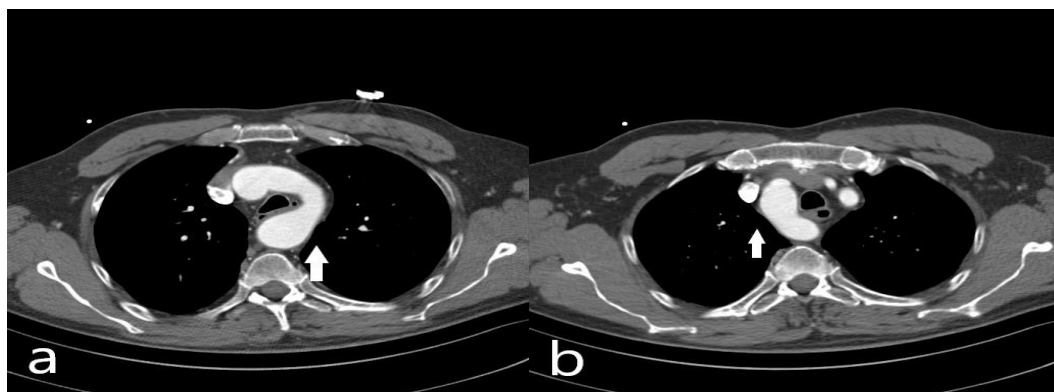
Axial CTA demonstrating double aortic arch with dominant right arch encircling and compressing the trachea and esophagus, white arrows, a) and b)
